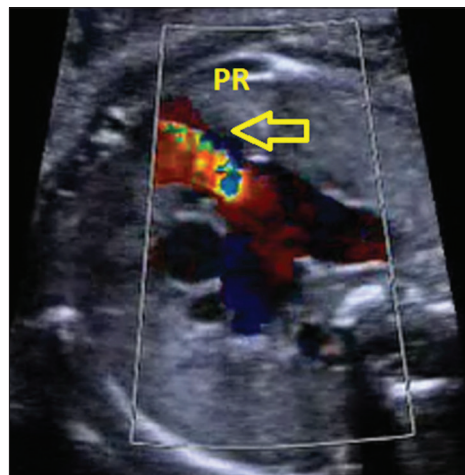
Color Doppler (short-axis view) shows the significant pulmonary valve regurgitation
